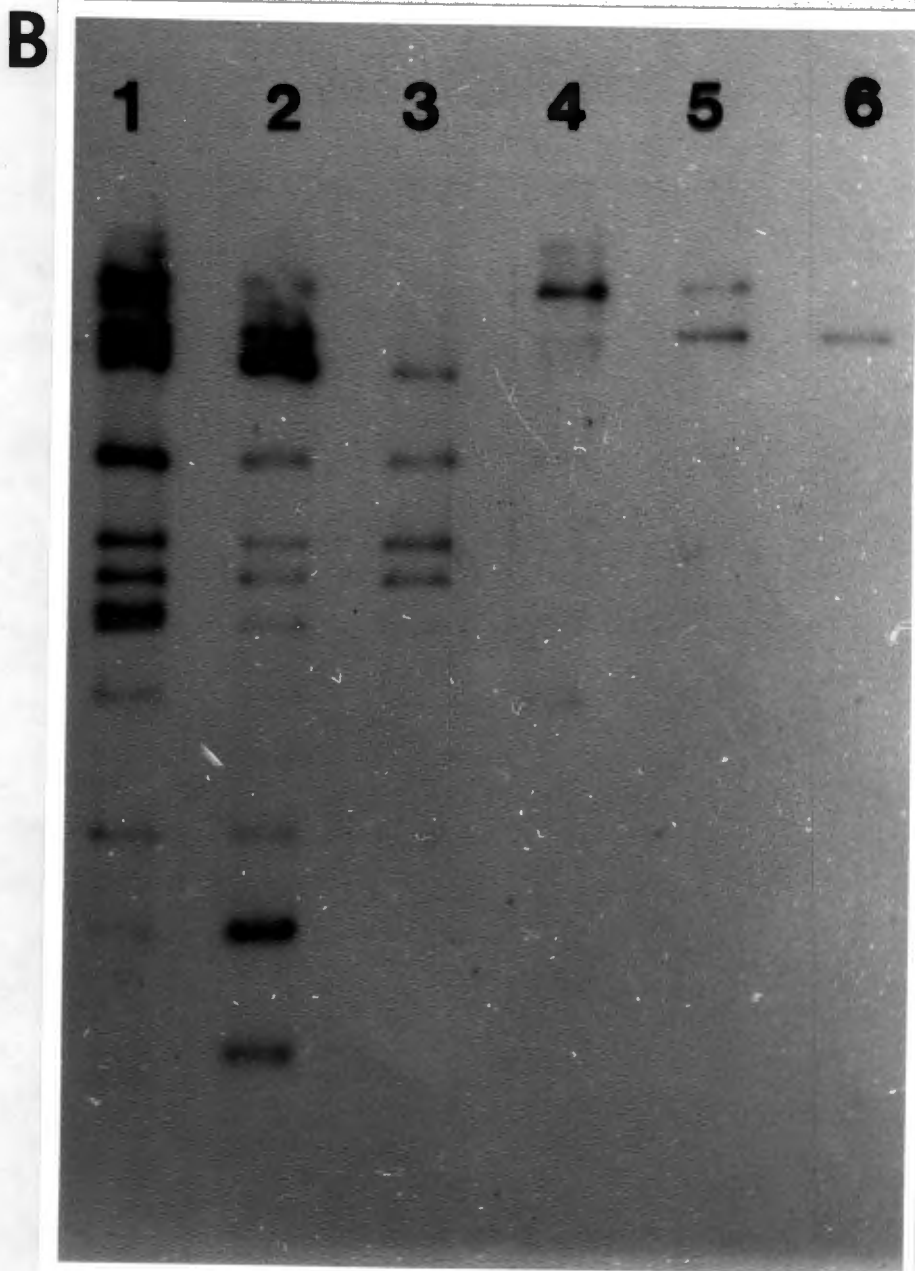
(A & B): Autoradiograph of Sq 249 Pst I ³²P-labelled fragments hybridized to a Mp Denmark Pst I blot (A) and a Mp Denmark Hind III blot (B). Lanes 1 - 6. 1: Sq 249 Pst I whole genome; 2: Pst I C; 3: Pst I D; 4: Pst I H; 5: Pst I O+P; 6: Pst I Q. X-ray film exposed overnight.
